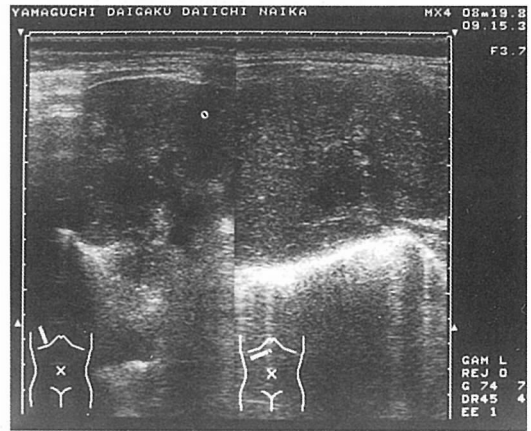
Ultrasonography on one day before admission. Some focal lesions with very low echoic pattern located in the right lobe of the liver.
